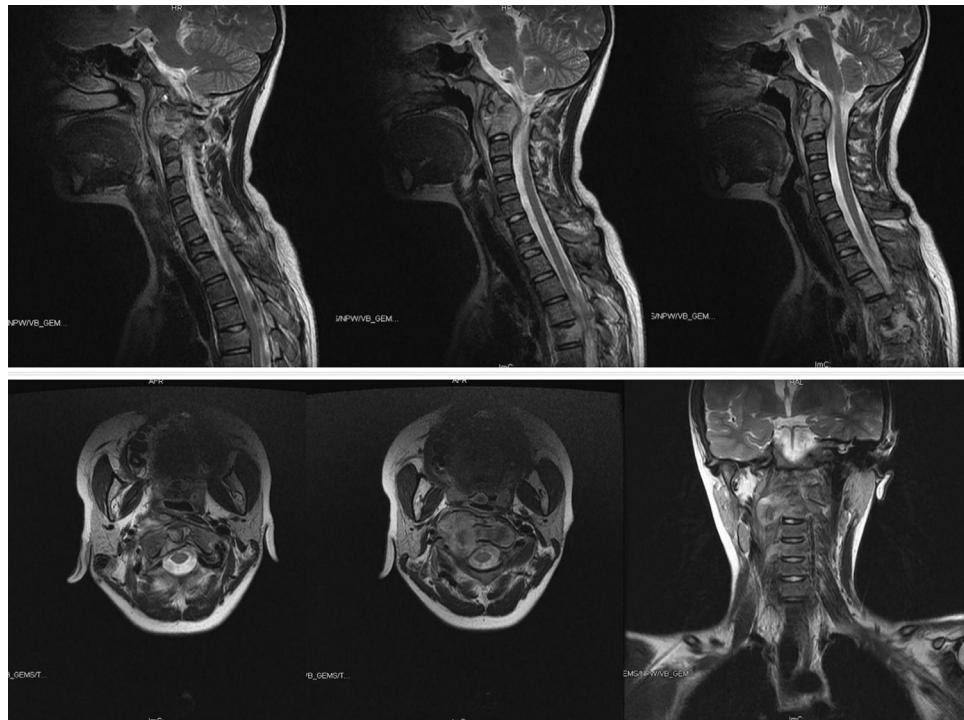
Cervical magnetic resonance imaging (T2) revealed deconstruction of C2 right side vertebral body by tumor. Tumor broke bony wall of vertebral body and extruded with paravertebral extension. T1 and T5 vertebral bodies were deconstructed with signal changing.
